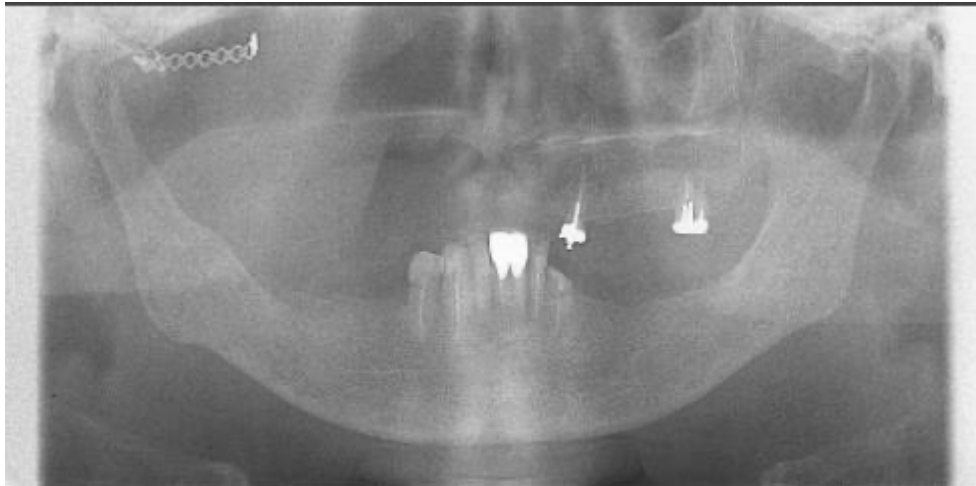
Panoramic radiograph taken 7 years after surgery.
